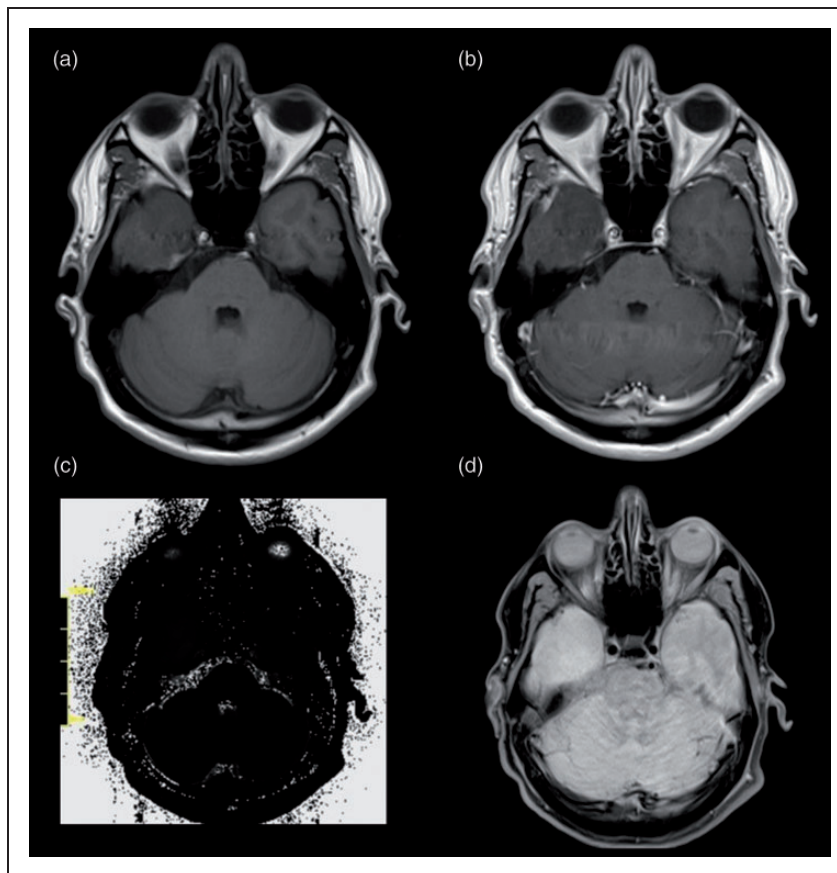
Patient, 38 years old, with a homogenous IDHw grade III glioma located in the lower temporal lobe (a) and without a significant pos. CE in the T1CE-sequence (b). (c) Shows the original raw T2 Map while (d) shows the corresponding FLAIR-sequence without a large oedema.
